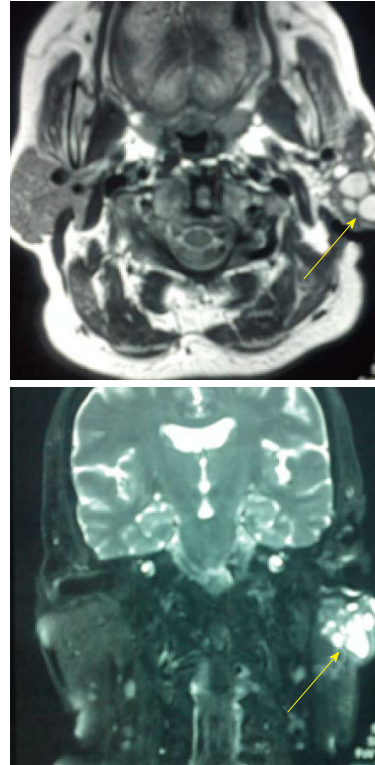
Magnetic resonance imaging in coronal and axial planes showing a multilobular tumor of the left parotid gland.
